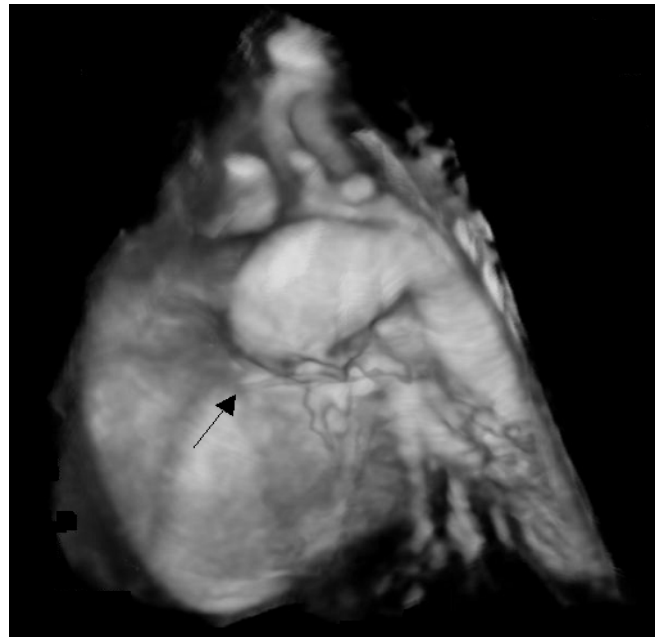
3D reconstructed CT obtained four days after birth. A large aneurysm (arrow) is seen.
